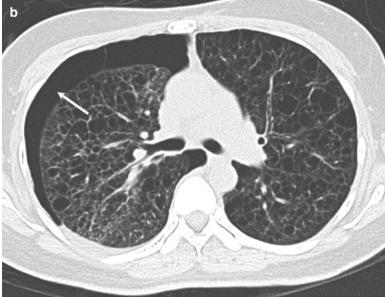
Woman with tuberous sclerosis complex presenting to the emergency department with spontaneous pneumothorax. (a) Frontal chest radiograph shows a chest tube in the right hemithorax with subtle cystic changes in the lower lungs. Consolidation (white arrow) in the right lower zone is probably focal re-expansion edema. (b) Axial CT
